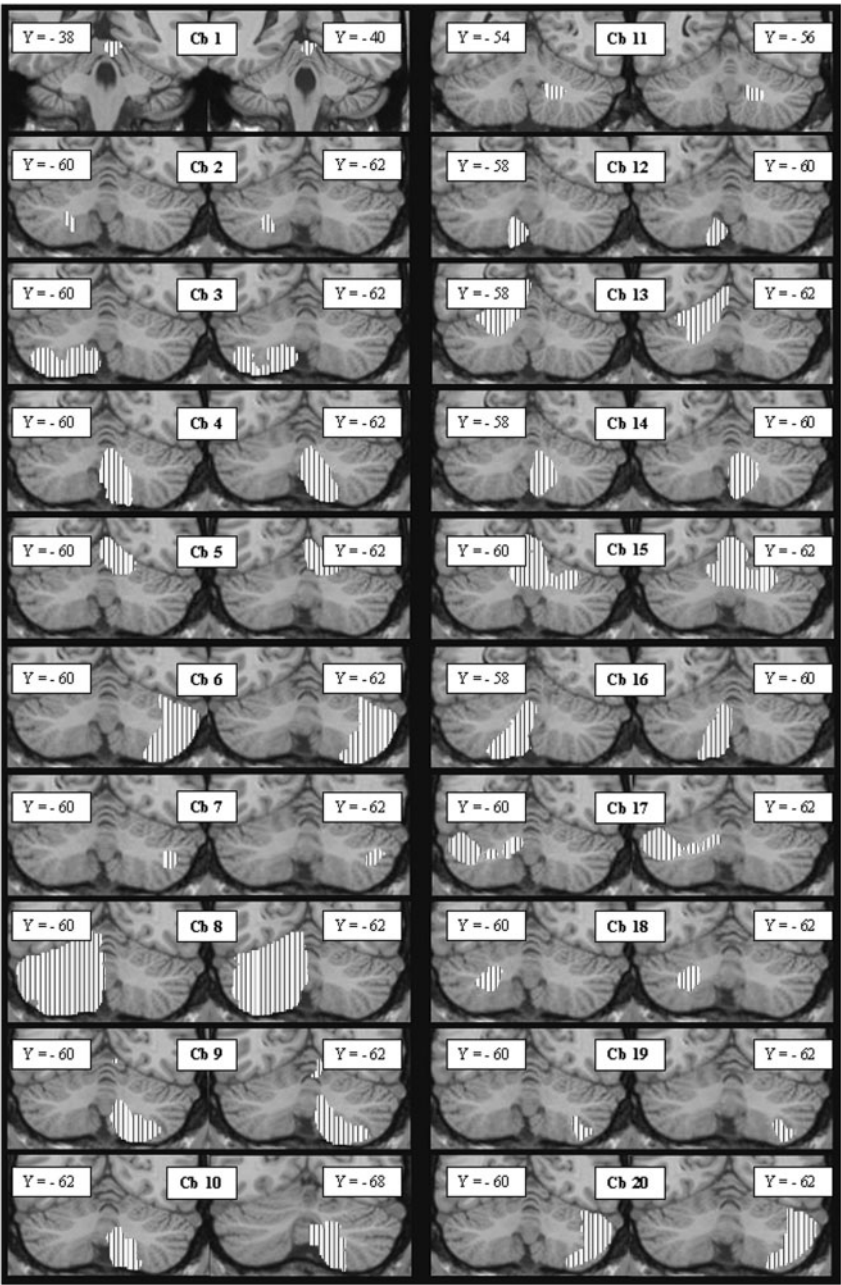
Experiment 2. Subjects with focal lesions: lesion extent in two representative coronal sections for each individual. Lesion is presented as overlaid on coronal T1-weighted template from (Schmahmann *et al.*, 2000). Lesion extensions were assessed on the 3D-T1-MPRAGEs after spatial normalization. Case codes as in Table 4.
